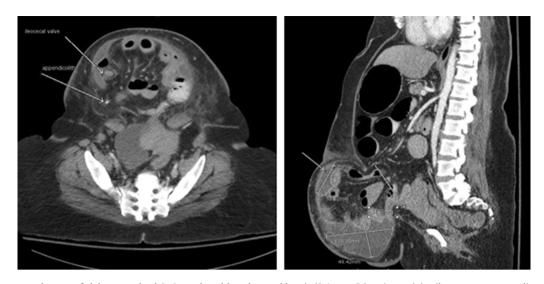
Computed tomography scan of abdomen and pelvis. Large, broad-based ventral hernia $(8.4-\text{cm} \times 5.9-\text{cm})$ containing ileum, cecum, appendix, and some ascending colon, with dilatation of proximal small bowel loops without passage of contrast into normal caliber exiting loops of colon, concerning for high grade small bowel obstruction. Within the hernia sac, the appendix is slightly dilated to 7.5 mm, with two appendicoliths found within the lumen. The bowel walls within the hernia sac are thickened, with prominent fat stranding. There are two adjacent fluid collections, measuring $10.8 \times 4.9 \times 10.4$ -cm and $1.4 \times 3.8 \times 5.2$ -cm, containing locules of gas, suggestive of abscess.
